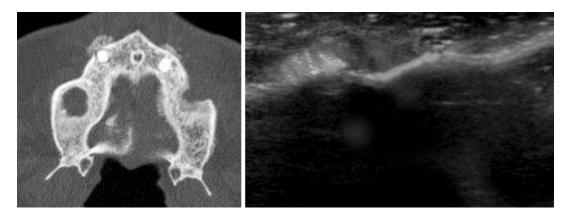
Osteosarcoma. Axial CBCT and USG slice reveal bilateral spicular periosteal reaction at buccal cortical plate of maxillary anterior region which is characteristic of osteosarcomas
